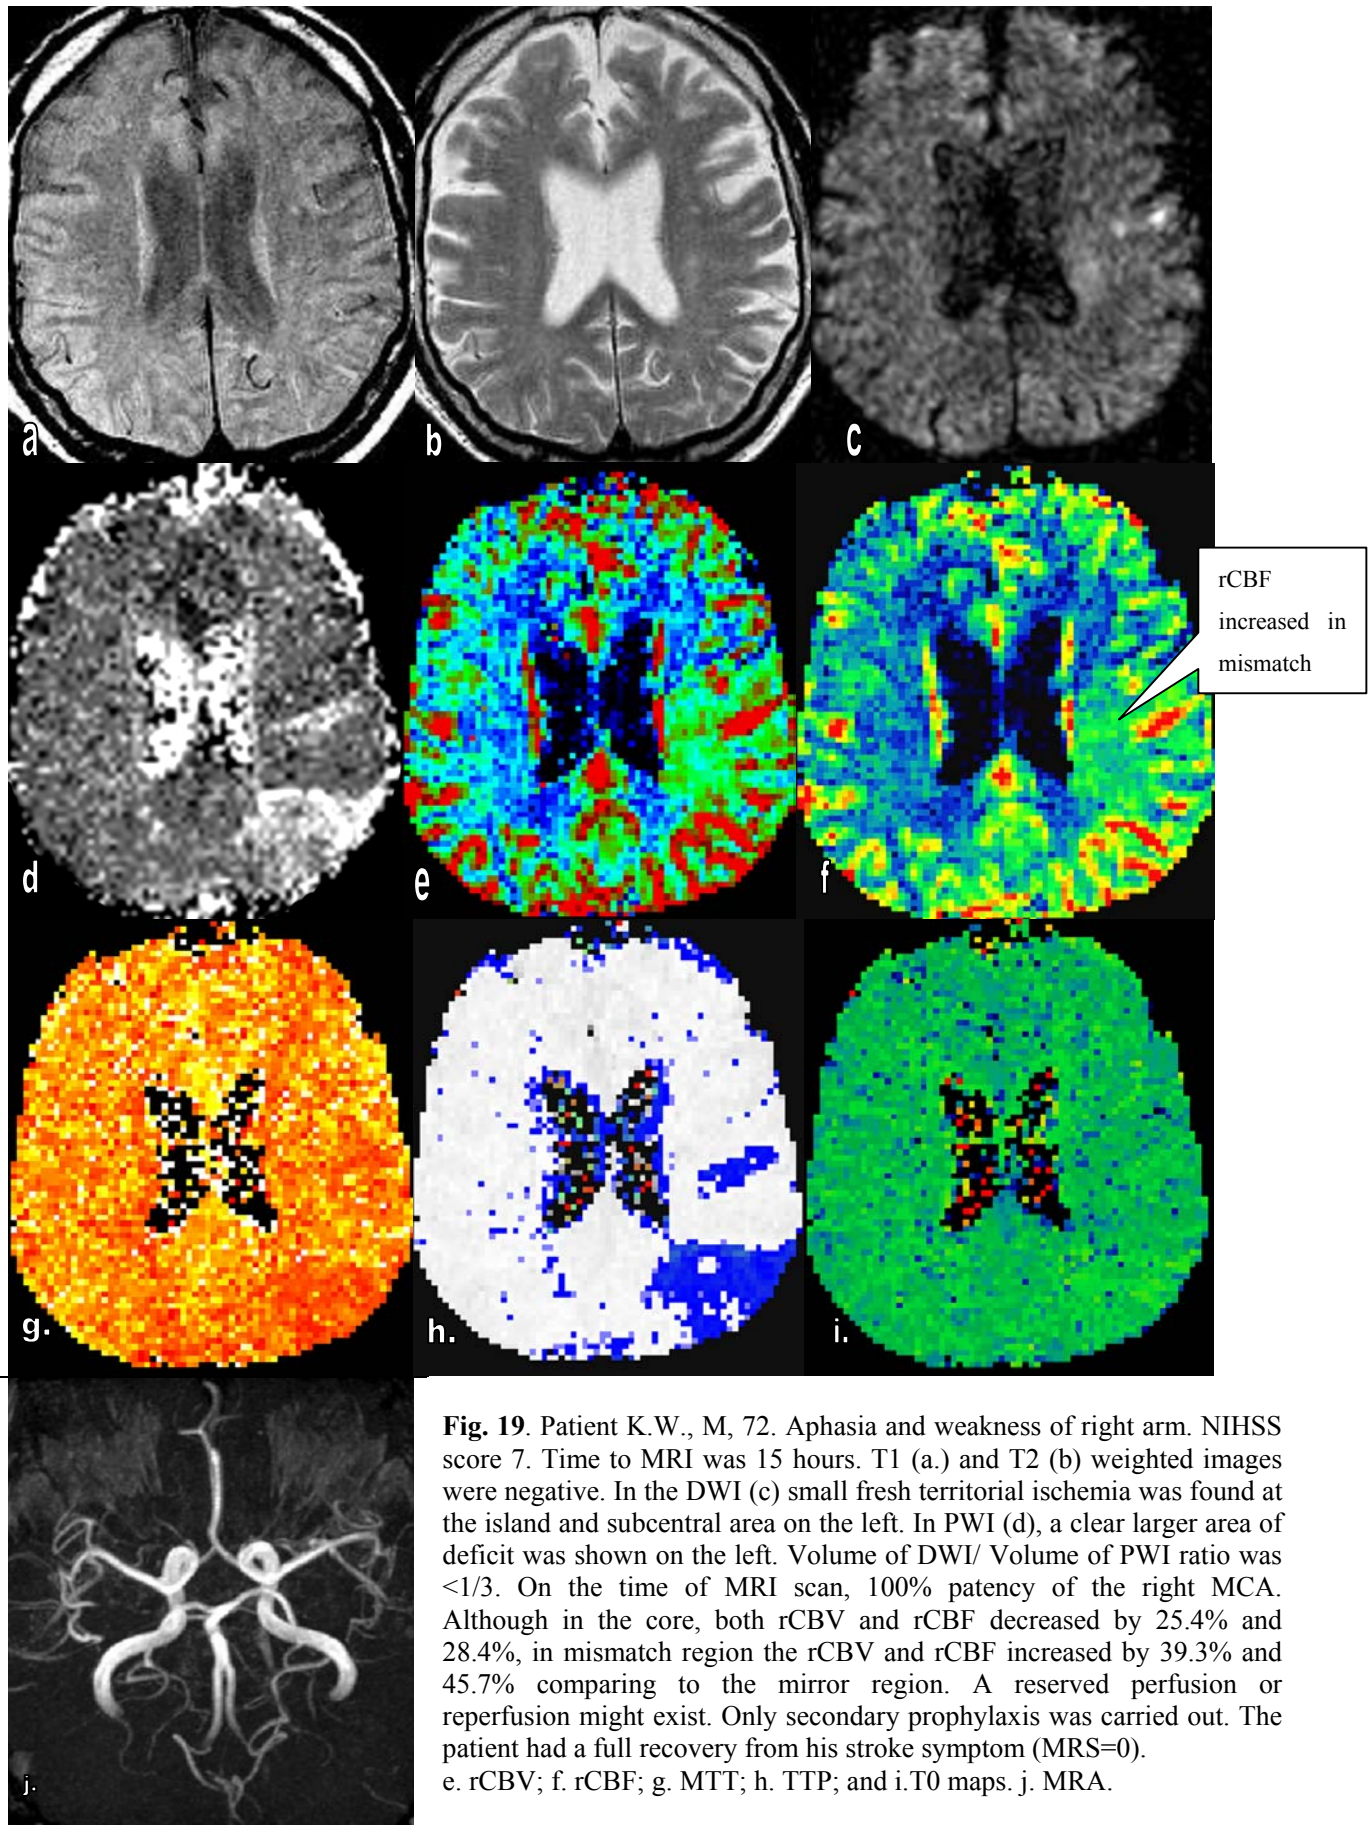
Patient K.W., M, 72. Aphasia and weakness of right arm. NIHSS score 7. Time to MRI was 15 hours. T1 (a.) and T2 (b) weighted images were negative. In the DWI (c) small fresh territorial ischemia was found at the island and subcentral area on the left. In PWI (d), a clear larger area of deficit was shown on the left. Volume of DWI/ Volume of PWI ratio was $<1/3$. On the time of MRI scan, 100% patency of the right MCA. Although in the core, both rCBV and rCBF decreased by 25.4% and 28.4%, in mismatch region the rCBV and rCBF increased by 39.3% and 45.7% comparing to the mirror region. A reserved perfusion or reperfusion might exist. Only secondary prophylaxis was carried out. The patient had a full recovery from his stroke symptom (MRS=0). e. rCBV; f. rCBF; g. MTT; h. TTP; and i. T0 maps. j. MRA.
